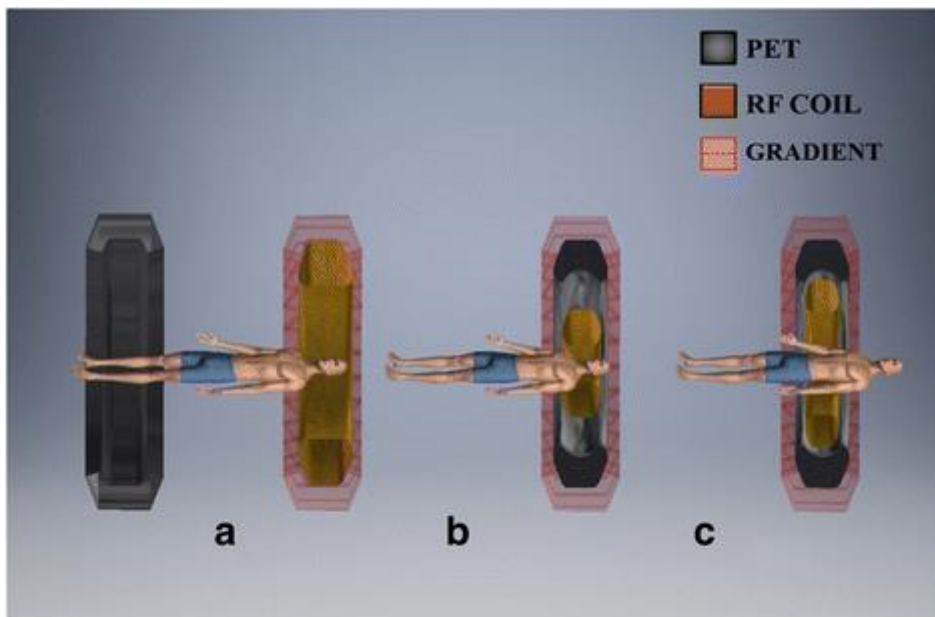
Multiple arrangements of PET/MRI: (a) Sequential layout, (b) Simultaneous PET place MRI scanning device, and (c) Simultaneous completely integrated structure (17).
